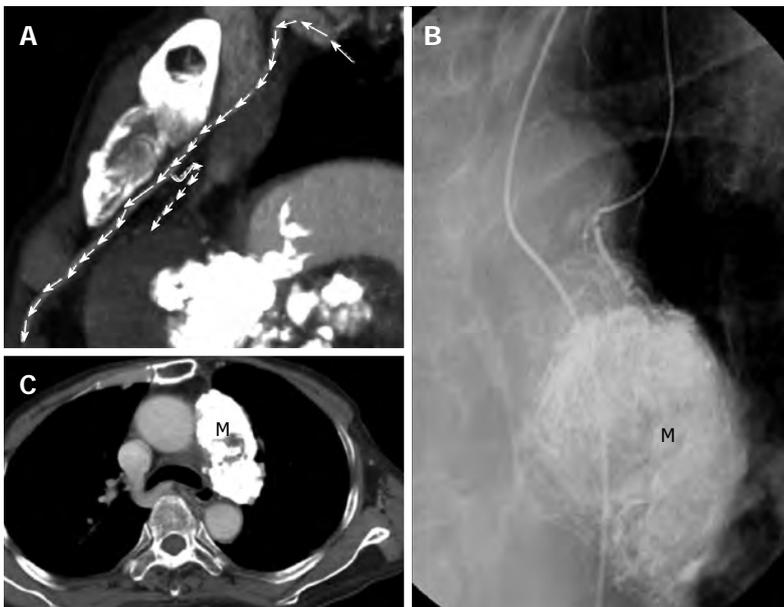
Successful control of mediastinal metastasis via selection of the supplying vessel. A: Multi-detector row computed tomography showed a supplying artery from small branch of left internal mammary artery to residual tumor (arrows); B: Tumor supplying artery of left internal thoracic (mammary) artery was selected via a 3 Fr microcatheter. Transarterial embolization for tumor (M) was done by using 6 mL of lipiodol; C: Follow-up chest computed tomography showed the metastatic tumor (M) in left anterior mediastinum was well embolized.
